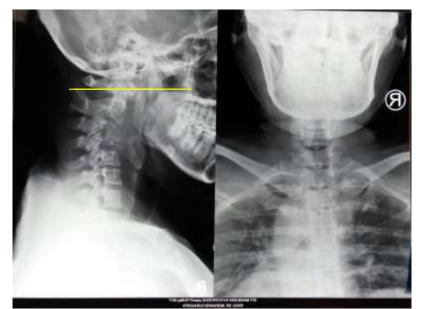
AP Lateral Cervical X-Ray. A 140 Kyphotic deformity was shown above
